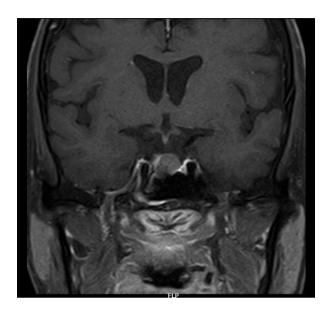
MRI coronalimage showing heterogeneous tumor with capsular enhancement and thin sellarfloor
